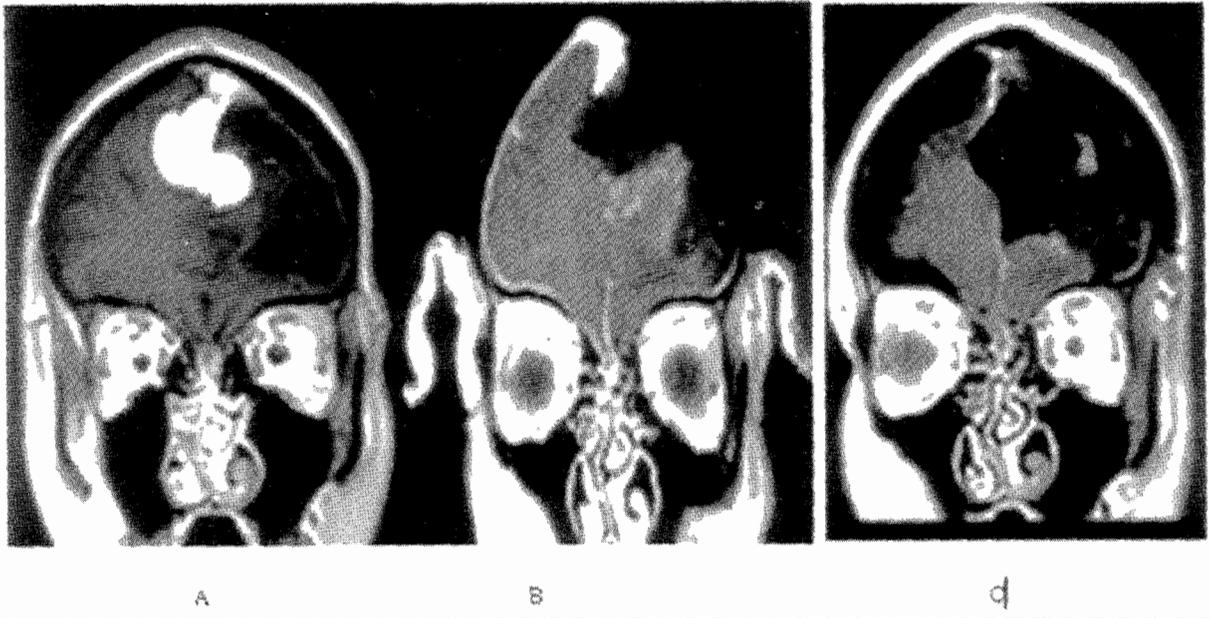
Contrast enhanced T1 intraoperative MRI images (Coronal views). A. Surgical planning images showing recurrent falcine meningioma B. Interdissection images showing unexpected residual tumour C. Quality assurance images showing complete tumour resection
